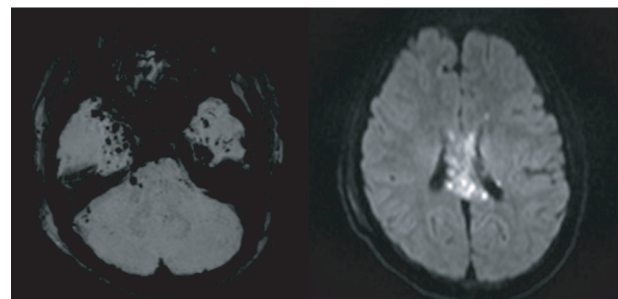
Head computed tomography and magnetic resonance imaging findings in a 16-year-old primiparous girl in the 11th week of gestation who was transported to our hospital in a comatose state with decerebrate posturing after a motorcycle injury. (a) Computed tomography on day 1 reveals left temporal lobe and corpus callosum contusion without mass effect signs or a midline shift, and fracture of the mandible (right). (b) Magnetic resonance imaging on day 2 shows diffuse petechial hemorrhage in the basal temporal lobe on fluid-attenuated inversion recovery imaging (left) and high signal intensity in the corpus callosum on diffusion-weighted imaging (right).
